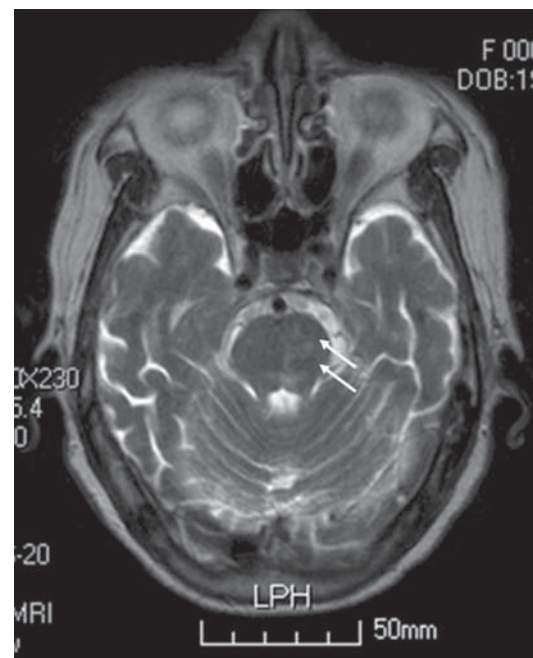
Same patient as in Figure 3. MRI demonstrates multiple foci of recent infarct on the left pons.
